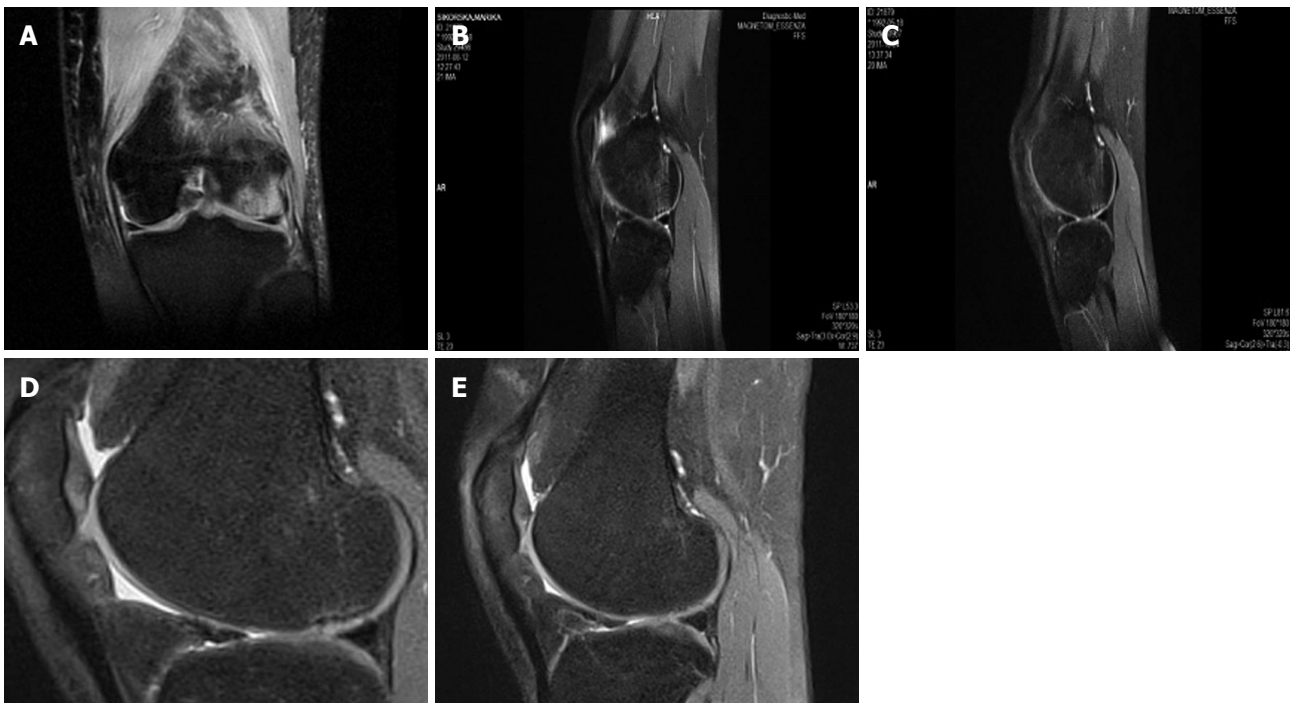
The same patient showing enhanced defect filling demonstrated by follow-up magnetic resonance imaging before surgery (A) and 3 (B), 6 (C), 12 (D) and 24 mo (E) after the index procedure.
